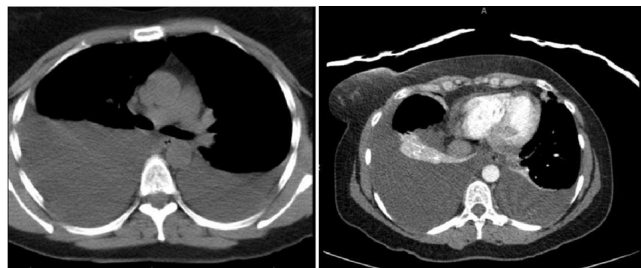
Angio-CT scan performed on the patient (bilateral pleural effusion).
